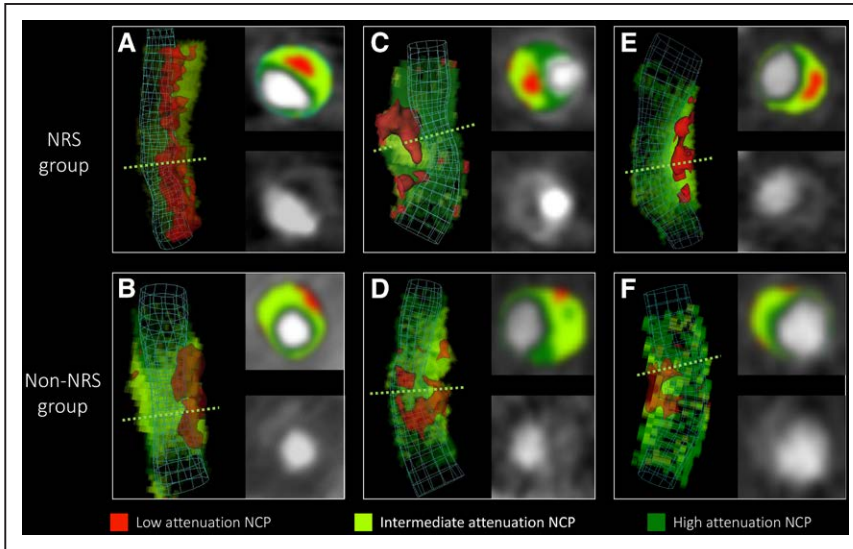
Representative images of plaques with or without the napkin-ring sign (NRS). Volume-rendered and cross-sectional images of plaques with NRS in the top (A, C, and E) and their corresponding matched plaques in the bottom (B, D, and F) are shown. Green dashed lines indicate the location of cross-sectional planes. Colors indicate different computed tomographic attenuation values. NCP indicates noncalcified plaque.
